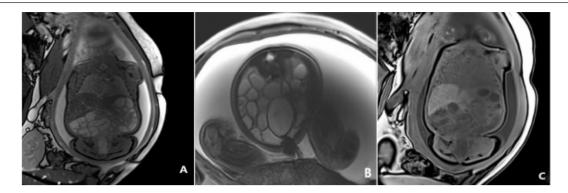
Fetal magnetic resonance imaging at 34 weeks of gestation
